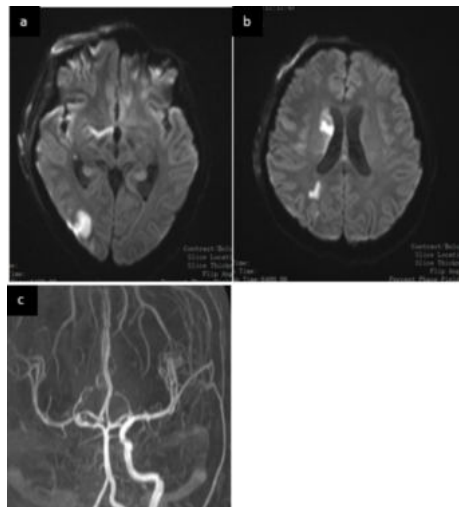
26 year old patient of ROCM with RT MCA infarct a) b) Diffusion restriction on DWI c) TOF MRA non visualization of RT MCA suggestive of thrombosis
